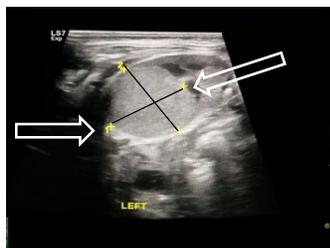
Ultrasound showing Echogenic Mass
